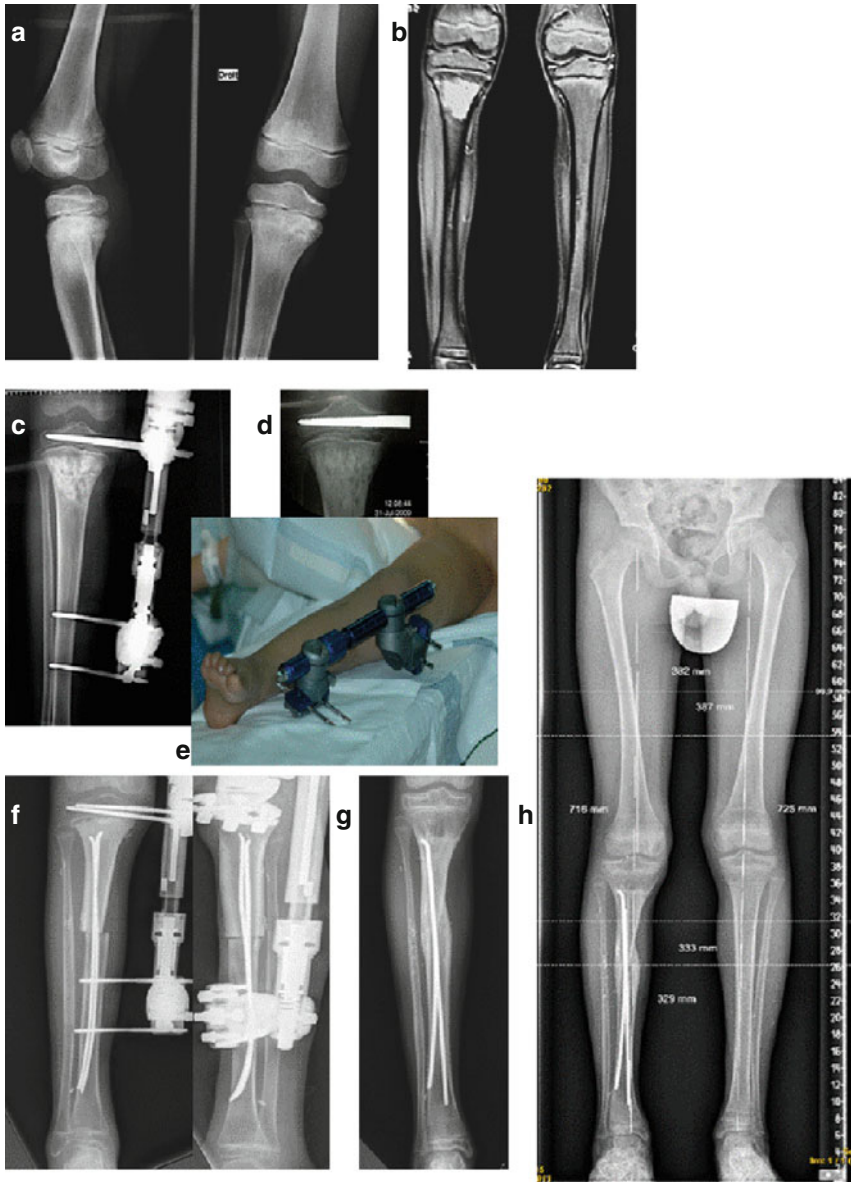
(a, b) X-ray and MRI of a Ewing's sarcoma in the proximal tibia of a 9-year-old boy. (c–e) Physeal distraction before excision. (f, g) After reconstruction with an intercalary bone allograft. The growth plate in this patient currently remains active (h), 60 months after surgery
